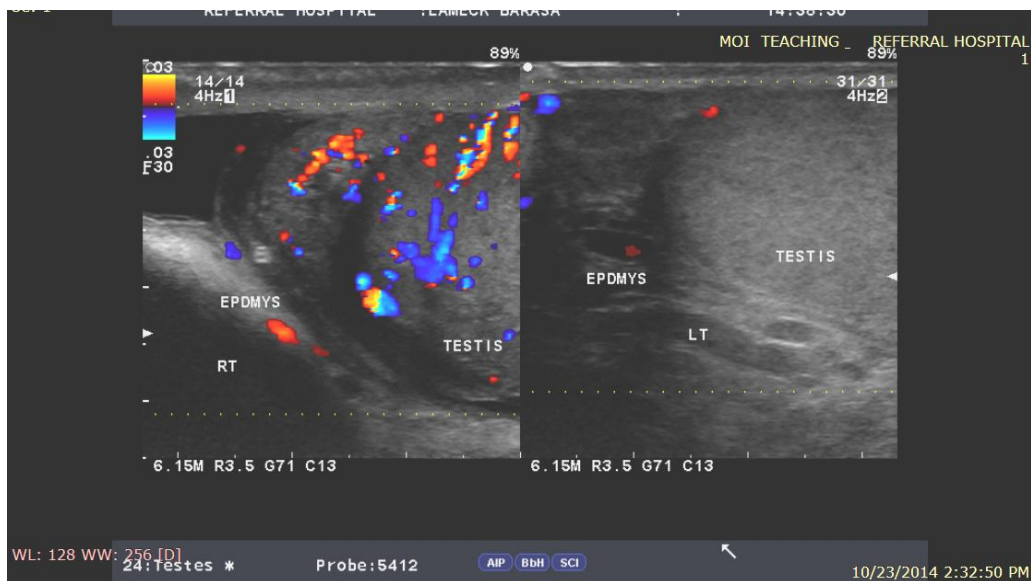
USG showing heterogenous echotexture of epididymal head and testis with increased vascularity on colour Doppler in epididymo-orchitis
